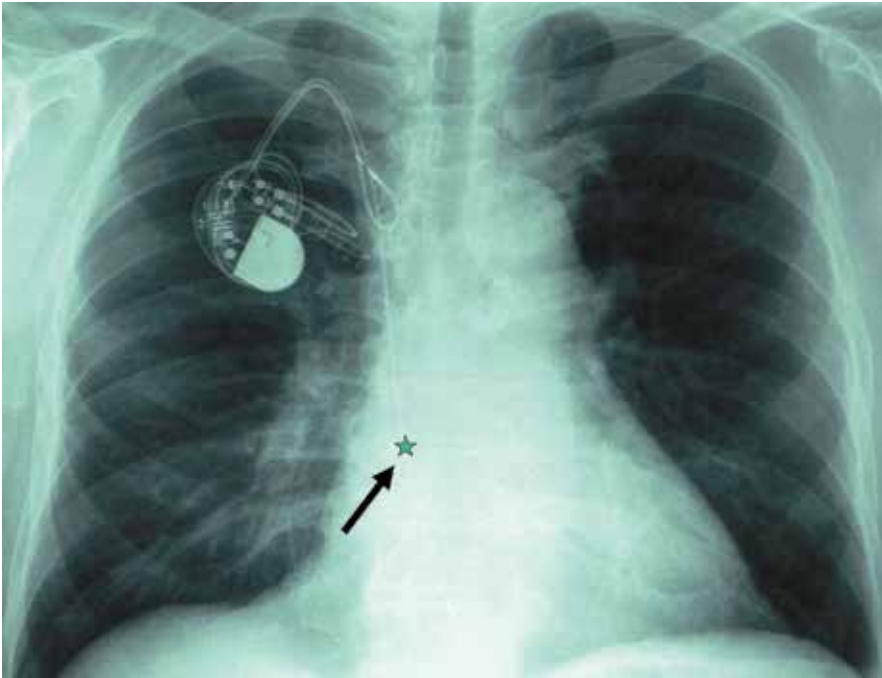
Chest X-ray showing displaced lead (ventricular lead tip indicated by the star).
